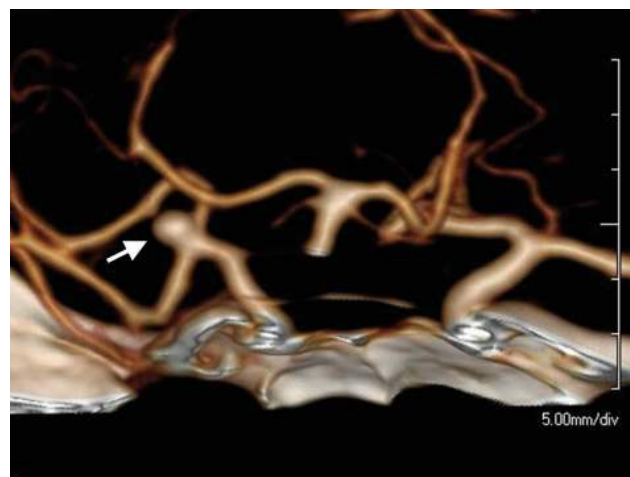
CT angiography of the candidate (Case 1) for lung transplantation showing an aneurysm at the left middle cerebral artery (arrow)
